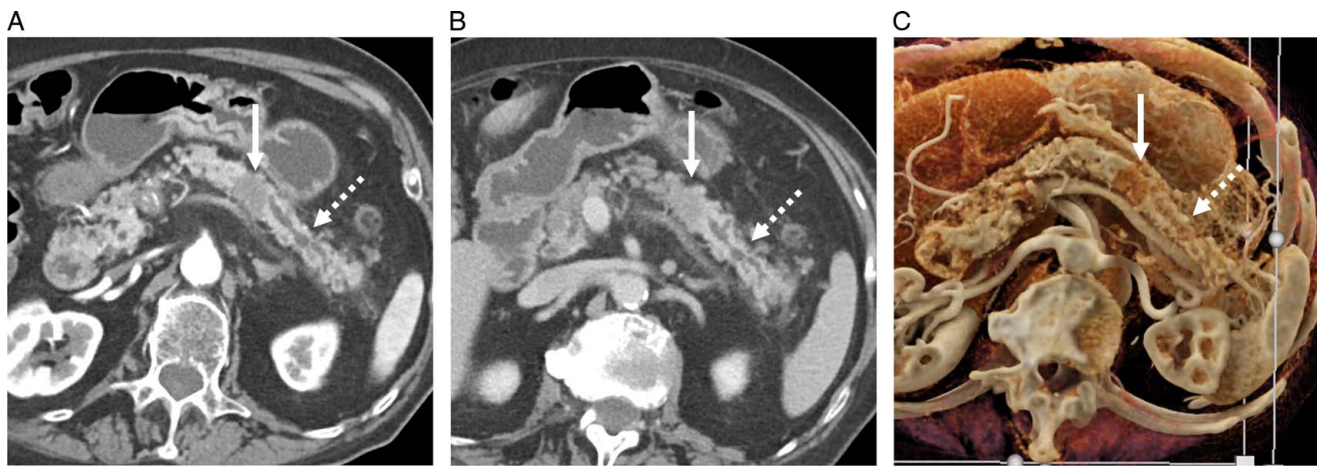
An 85-year-old woman with resectable pancreatic ductal adenocarcinoma. Axial intravenous (i.v.) contrast-enhanced computed tomography (CT) images in the arterial phase (A) and portal venous phase (B) demonstrated a subtle hypoenhancing mass arising from the body of the pancreas (arrows) with mild dilatation of the pancreatic duct in the body and tail (dotted arrows). (C) Cinematic rendering of the axial i.v. contrast-enhanced CT image accentuated the texture difference between the mass (arrow) and the background pancreatic parenchyma and improved lesion conspicuity. Mild dilatation of the pancreatic duct (dotted arrow) is visible. There was no evidence of vascular involvement, and the tumor was staged as resectable. The patient subsequently underwent a distal pancreatectomy.
